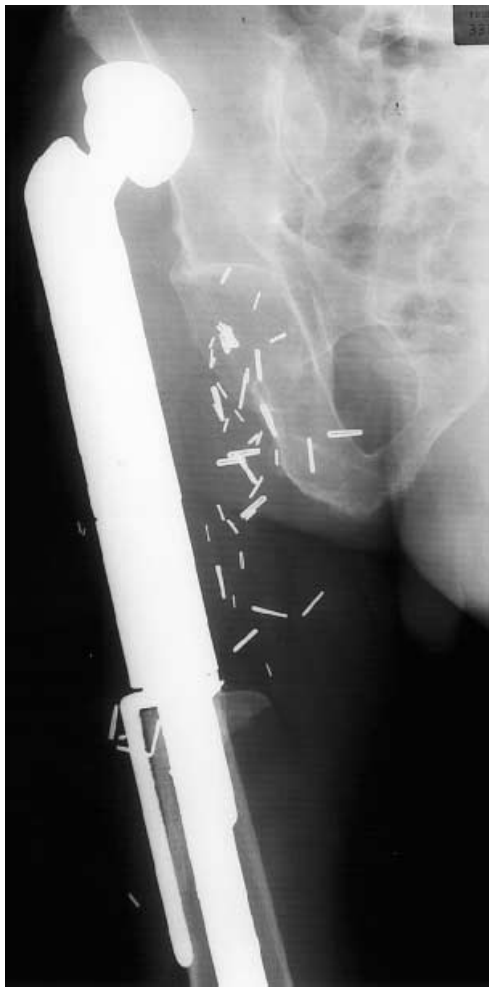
Radiograph of patient with recurrent dislocation
